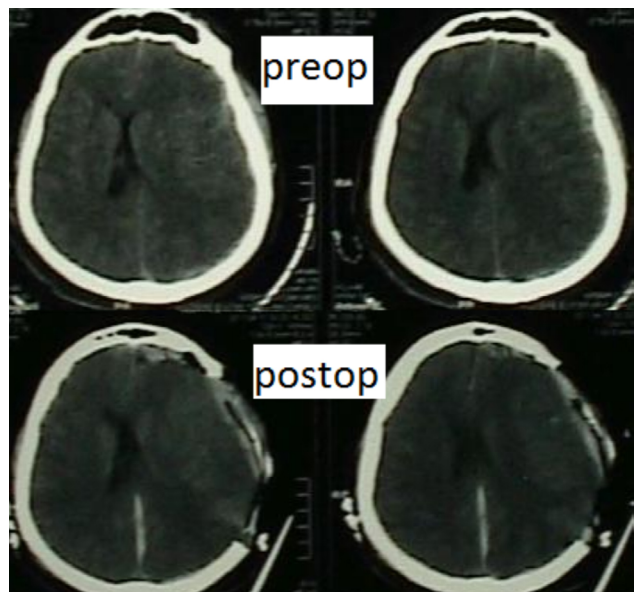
Preoperative and postoperative CT scans of a TBI patient.
